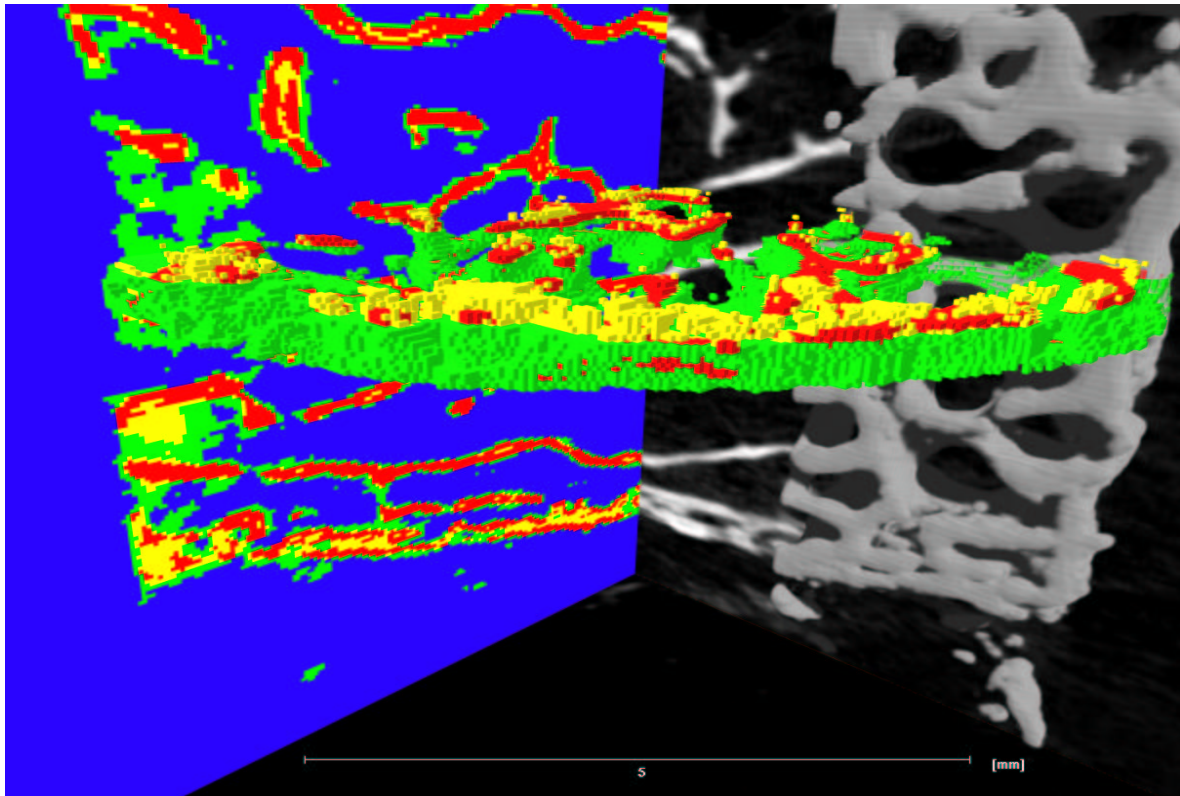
Similar area as shown at the bottom of figure 4. The left plane is a 2D sagittal reconstruction of symbol-encoded trabeculae, the right plane represents 2D and 3D reconstructions based on X-ray attenuation in the coronal direction. The transaxial fragment of the volume shows symbol-encoded trabeculae. Note the denser parts on both sides at the outer contour inside the biopsy. They represent bone dust within the marrow space due to the drilling extraction of the biopsy.
